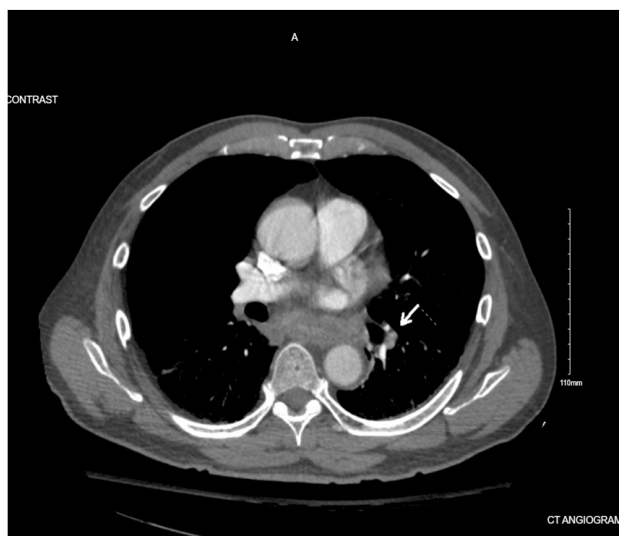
CT Angiogram showing Pulmonary Embolus in the intermediate branch of the pulmonary artery to the left lower lobe (White arrow)
